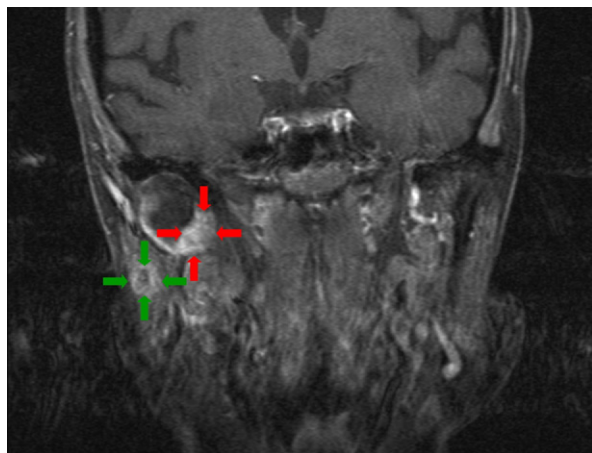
MRI scan presenting the tumor mass in the right TMJ (red arrows) and necrotic lymph node in the parotid gland (green arrows) (patient 2).
